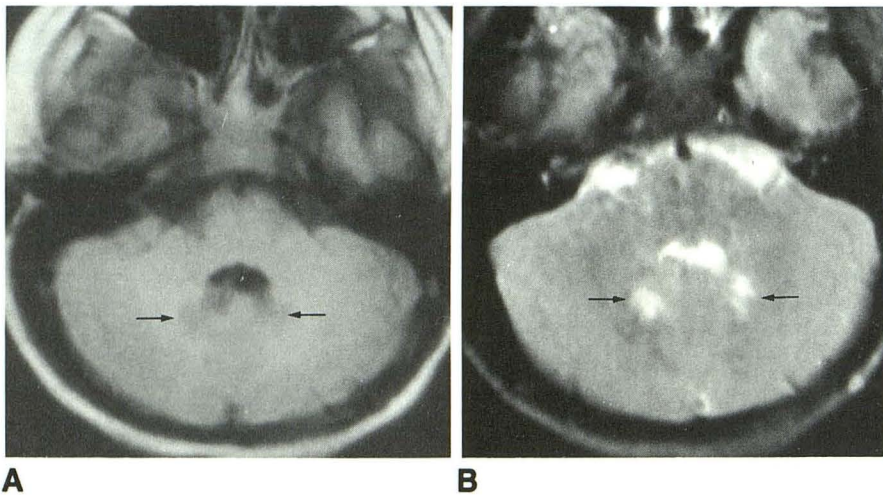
MR images of 10-year-old girl with infantile Refsum disease.
